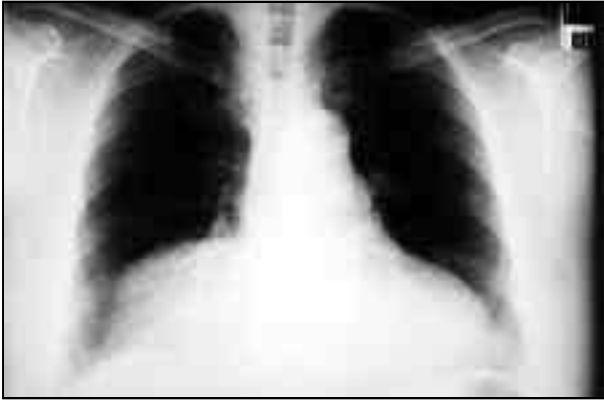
X-ray Chest showing a large complex shadow in the right hemithorax
